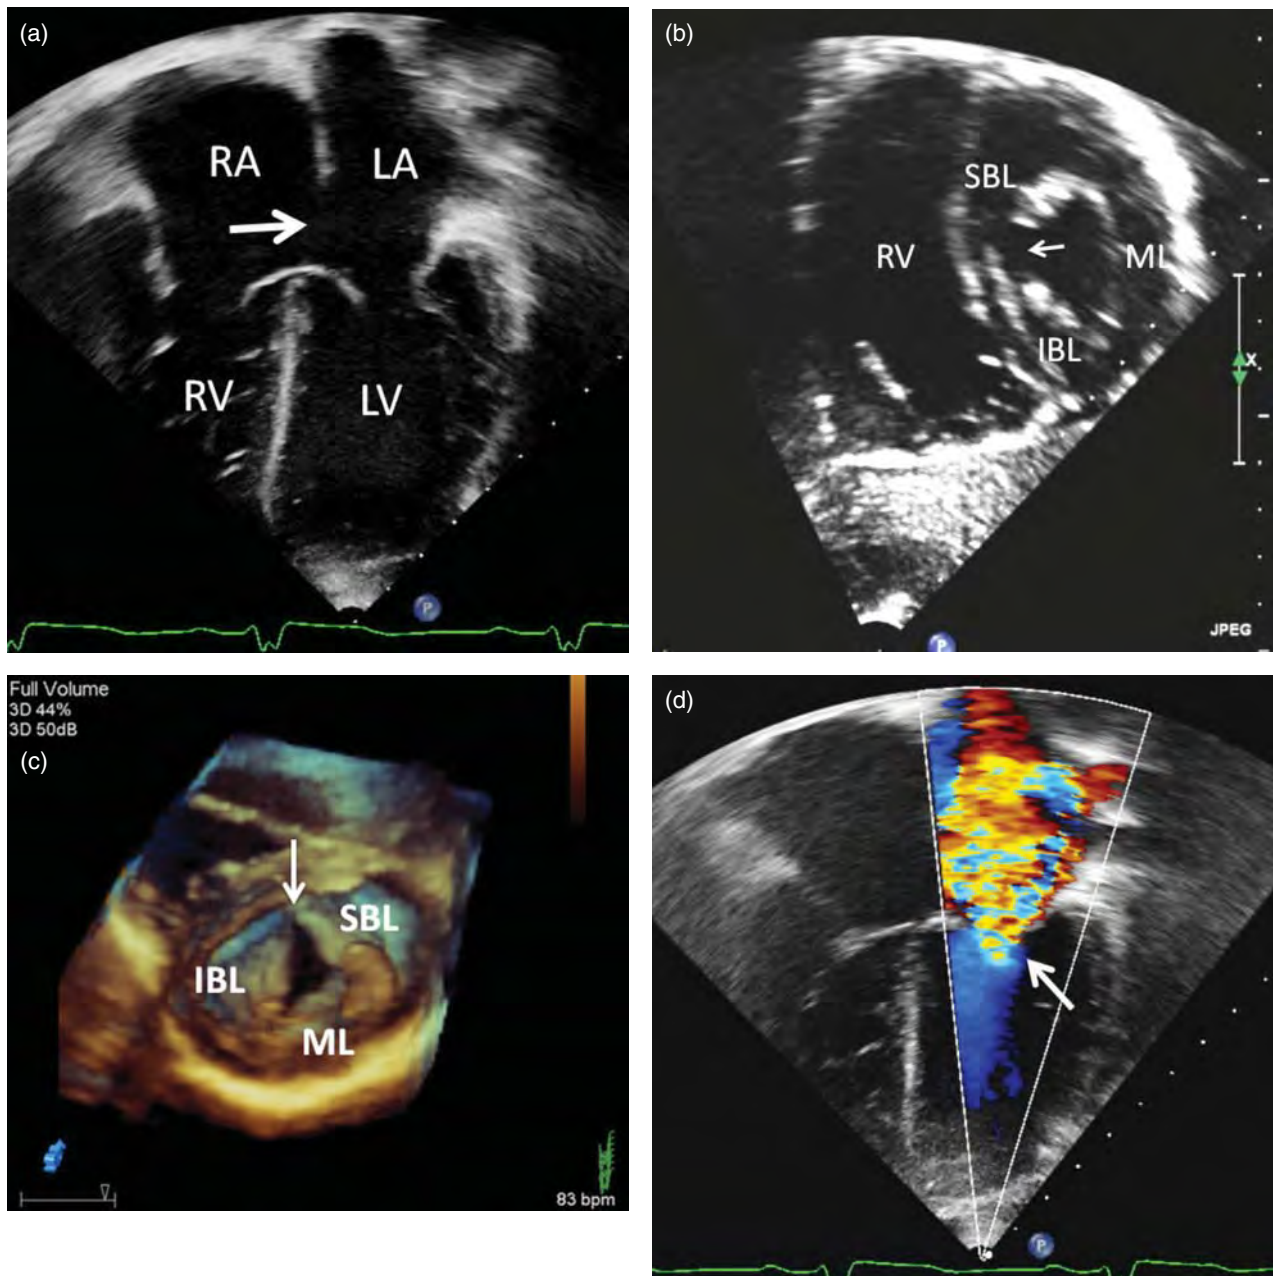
Primum ASD. (a) An echocardiographic four chamber view that demonstrates the atrioventricular (AV) valves hinging at the same level with a defect in the atrial septum just above the AV valves. This defect is a primum ASD. (b) The presence of a cleft in the left AV valve (arrow) as shown in this subcostal short-axis image is a critical component for the diagnosis of a primum ASD. The three left AV valve leaflets include the superior bridging leaflet (SBL), the inferior bridging leaflet (IBL), and the mural leaflet (ML), with a cleft between the SBL and IBL. (c) The anatomy of the left AV valve is even better demonstrated by three-dimensional echocardiography as shown in this image demonstrated as if one were looking up from the left ventricular apex. (d) As is true for many affected patients, there is often left AV valve insufficiency (arrow), which usually stems from the cleft between the SBL and IBL.
